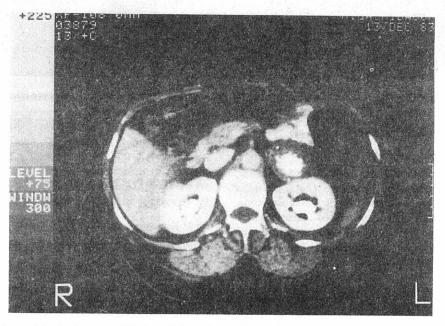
Postcontrast CT showed the lesion to be poorly enhanced. CT showed the lesion to be distinct from the pancreas and the superior pole of the left kidney.
